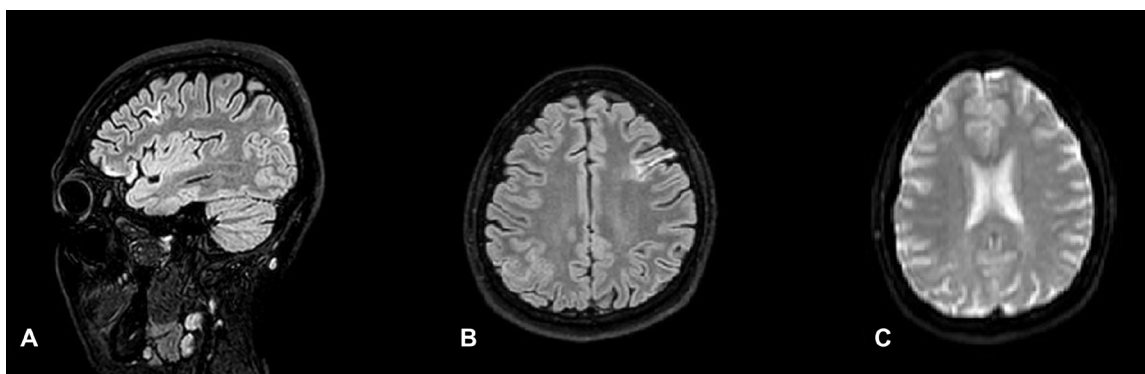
Magnetic Resonance Imaging showed almost complete resolution of brain hyperintensities 10 days later as shown both by FLAIR (A, B) and DWI (C) sequences.
